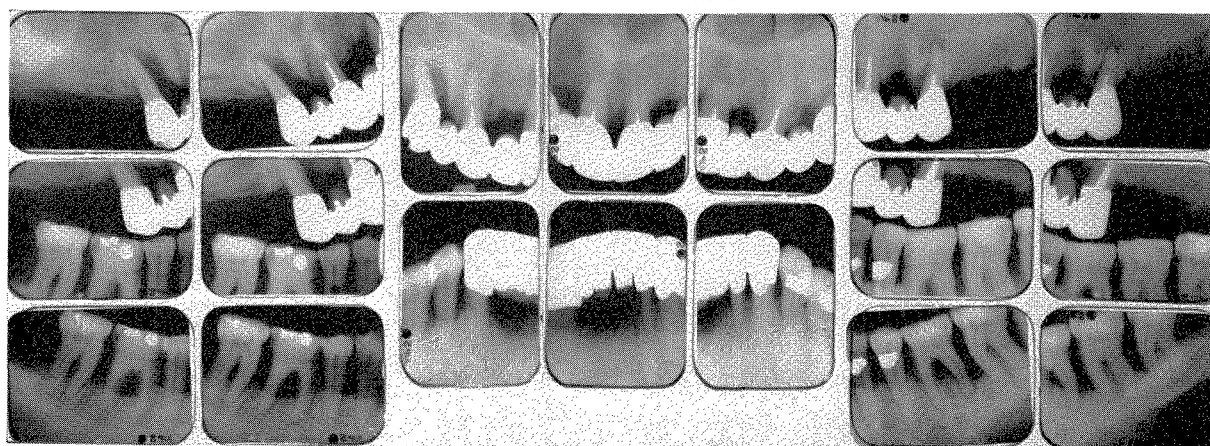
Roentgenograms taken in June, 1961, before the work was started. (See text.) (Figs. 457 and 458 are of the same case.)
